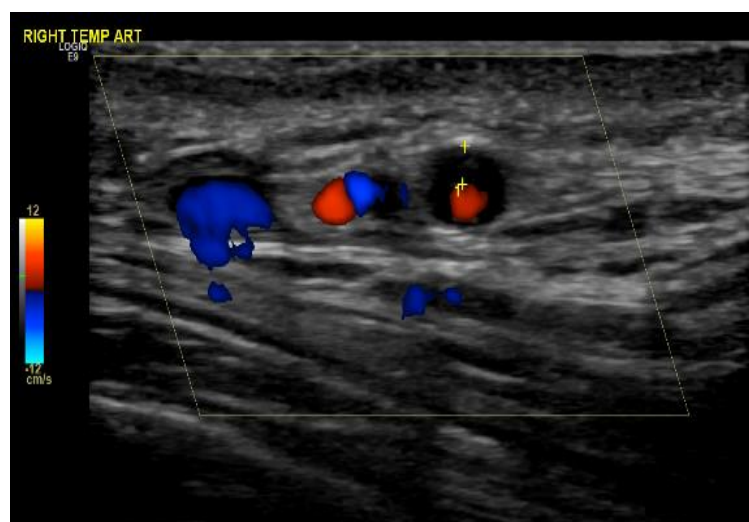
Temporal artery ultrasound - The dark area around the arterial lumen on ultrasonography (yellow crosses) is characteristic of the halo sign.
